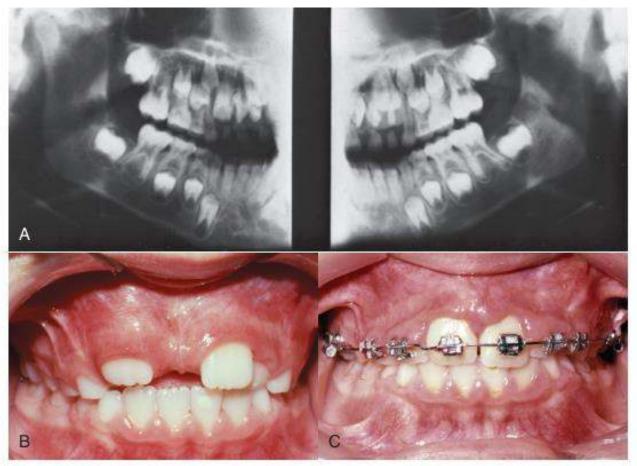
Multiple supernumerary teeth in the anterior maxilla, although rare, can cause spacing and delayed eruption of anterior teeth. A, This patient has an exceptionally wide diastema and delayed eruption of the maxillary lateral incisors. B, The panoramic radiograph reveals three supernumeraries of various shapes and orientations. Conical and noninverted supernumeraries usually erupt, whereas tubercle-shaped and inverted ones do not. C, The supernumeraries were removed, the diastema closed, and the incisors were aligned with fixed appliances after they erupted.
